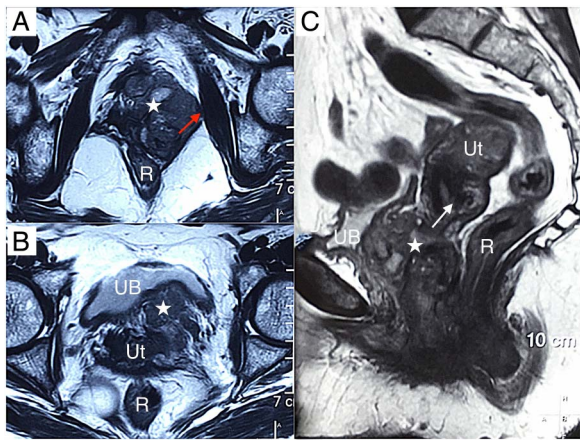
Contrast-enhanced MRI of the pelvis. (A) Axial section showing the mass lesion (star) indenting the left obturator internus muscle (red arrow). (B) Axial section showing the mass in relation to the urinary bladder anteriorly and rectum posteriorly. Note that despite indenting the urinary bladder, there is no evidence of definite invasion. (C). Coronal section showing the mass arising from the cervix (white arrow) and extending into the vagina. R, rectum; UB, urinary bladder; Ut, uterus.
